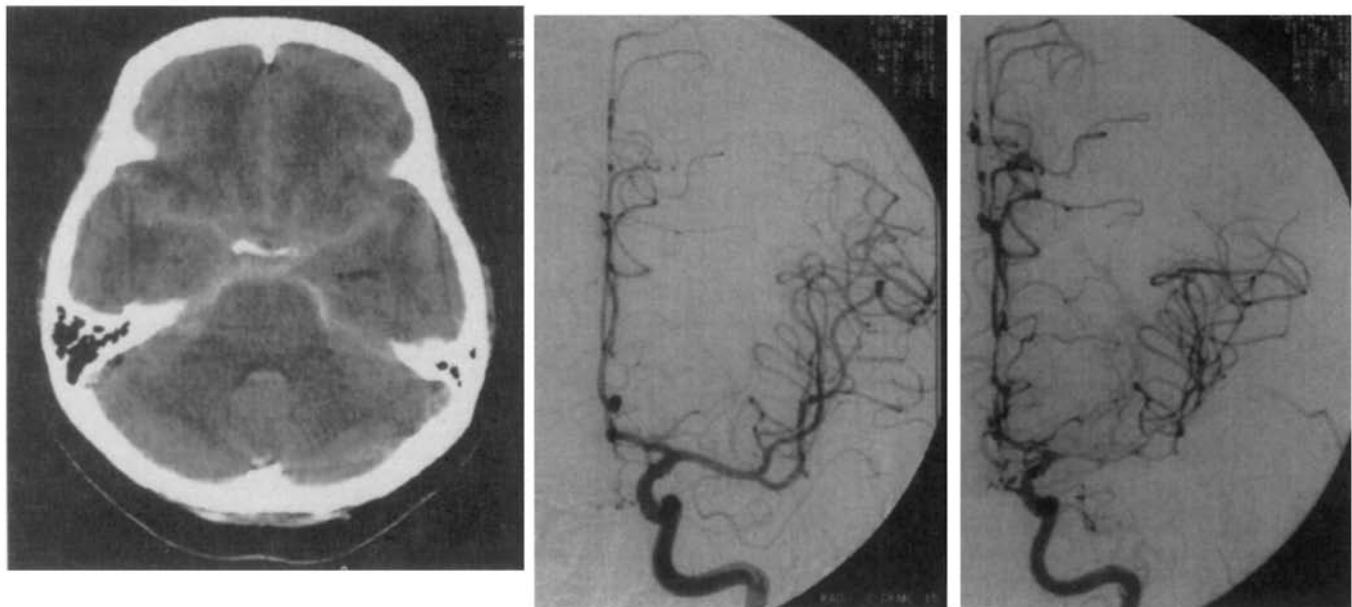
Preoperative computed tomographic scan of a 56-year-old female shows diffuse, thick clots in the basal cisterns (left). Initial cerebral angiography showed an aneurysm arising from the junction of the basilar and left superior cerebellar arteries. This aneurysm was clipped
